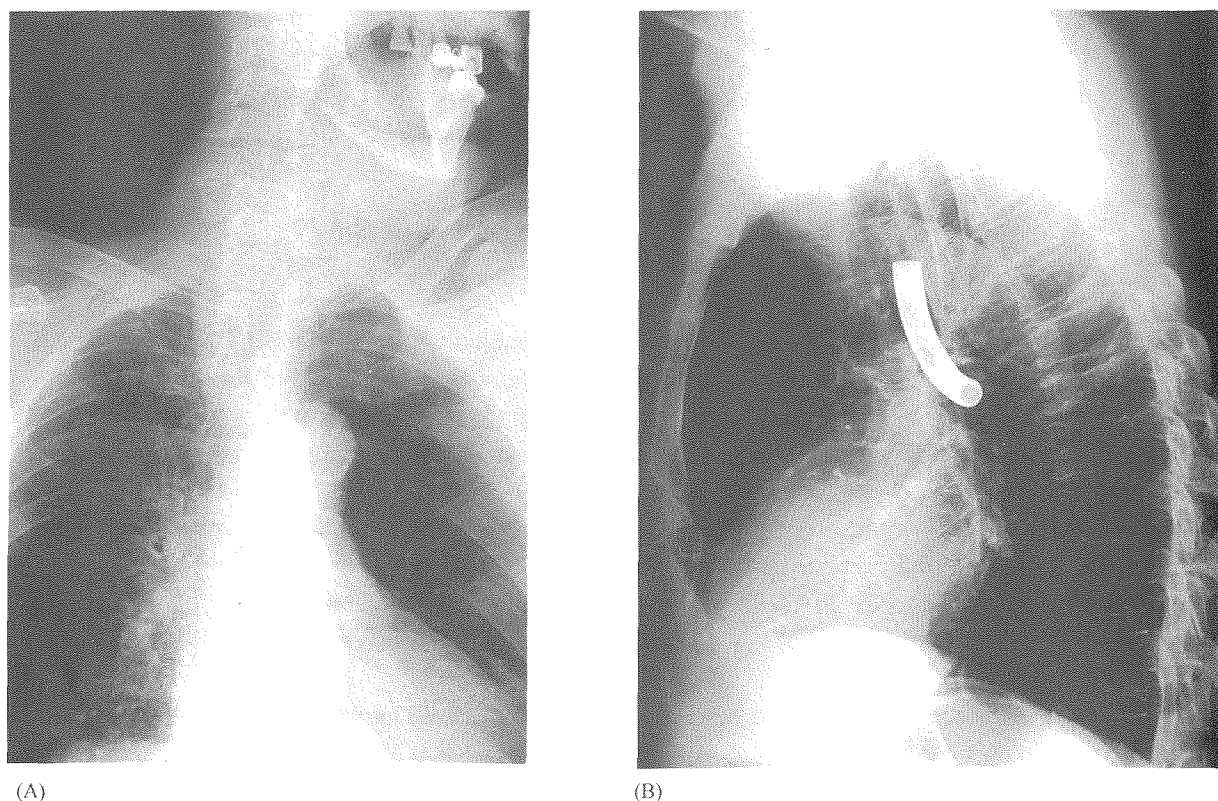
The posterior- anterior (A) and left lateral (B) chest radiographs showing a broken metallic tracheostomy tube lodged in the left main bronchus.
